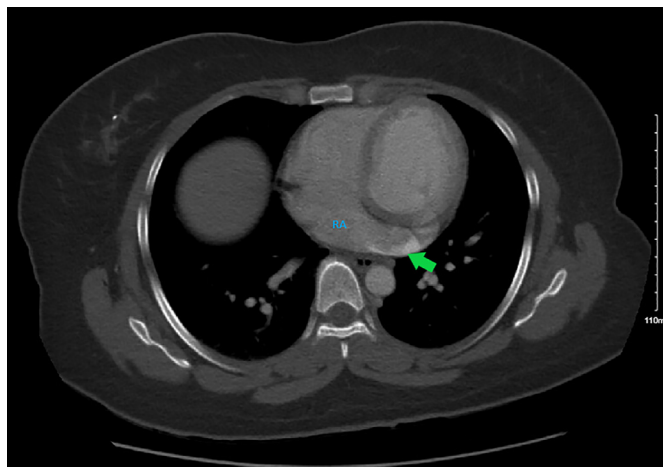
Axial view, CT angiogram of the thorax, vertebrae window, demonstrating the PLSCV (green arrow) draining into the right atrium (RA).
